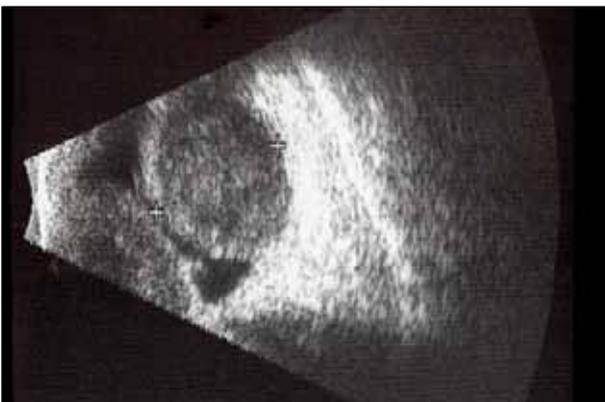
A B-scan ultrasound shows a kissing choroidal hemorrhage.
